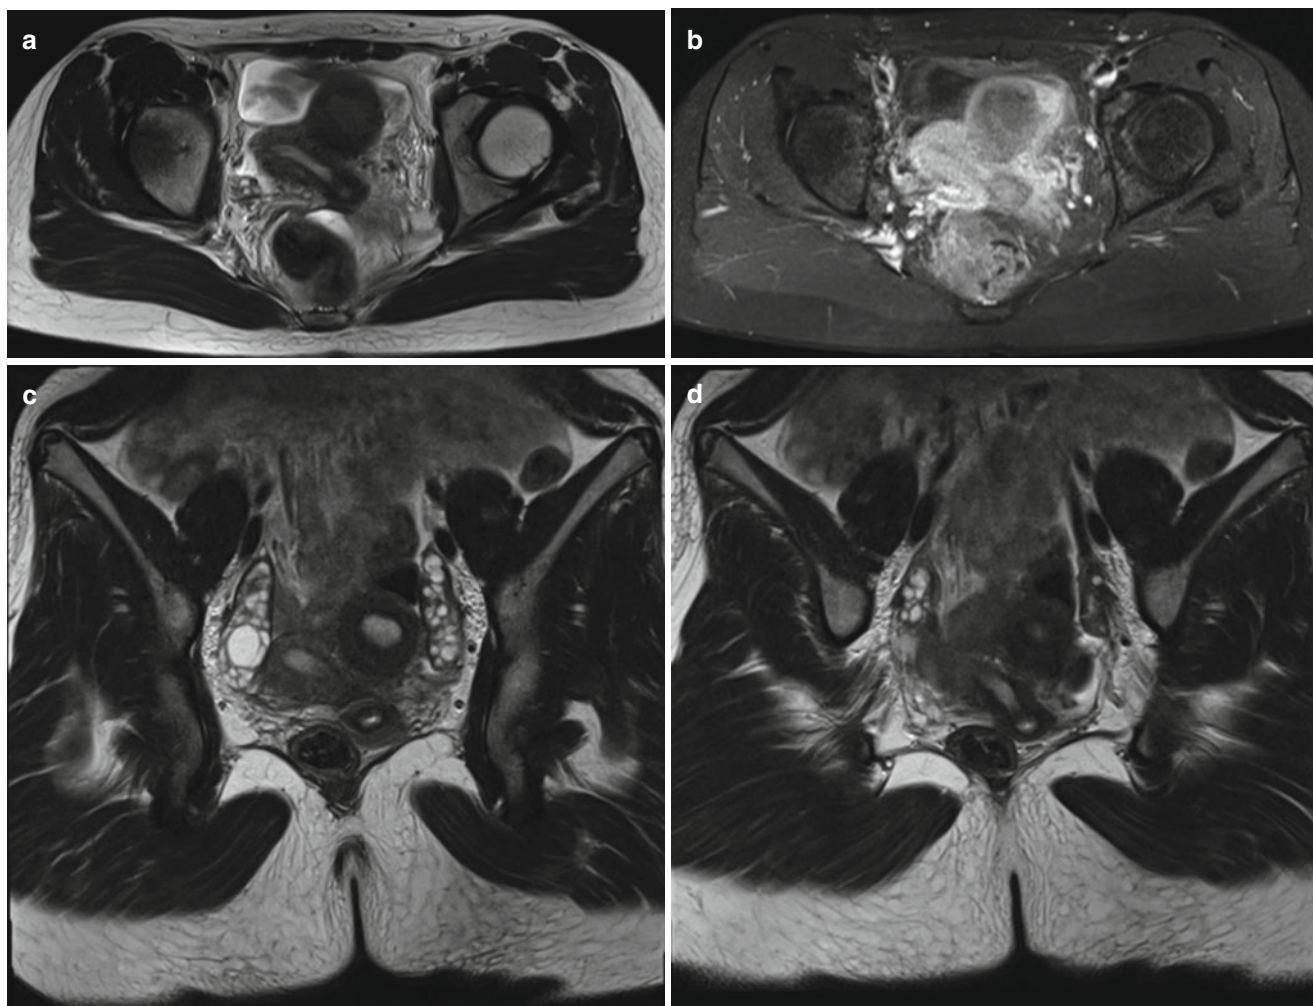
Unicornuate uterus with noncommunicating rudimentary horn in a 14-year-old girl. (a, c, d) T2-weighted MR images show unicornuate uterus and separated rudimentary horn containing endometrial
